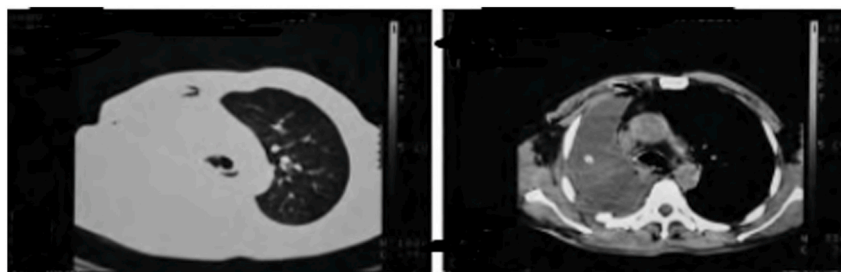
CT scan before installing the occluder.
